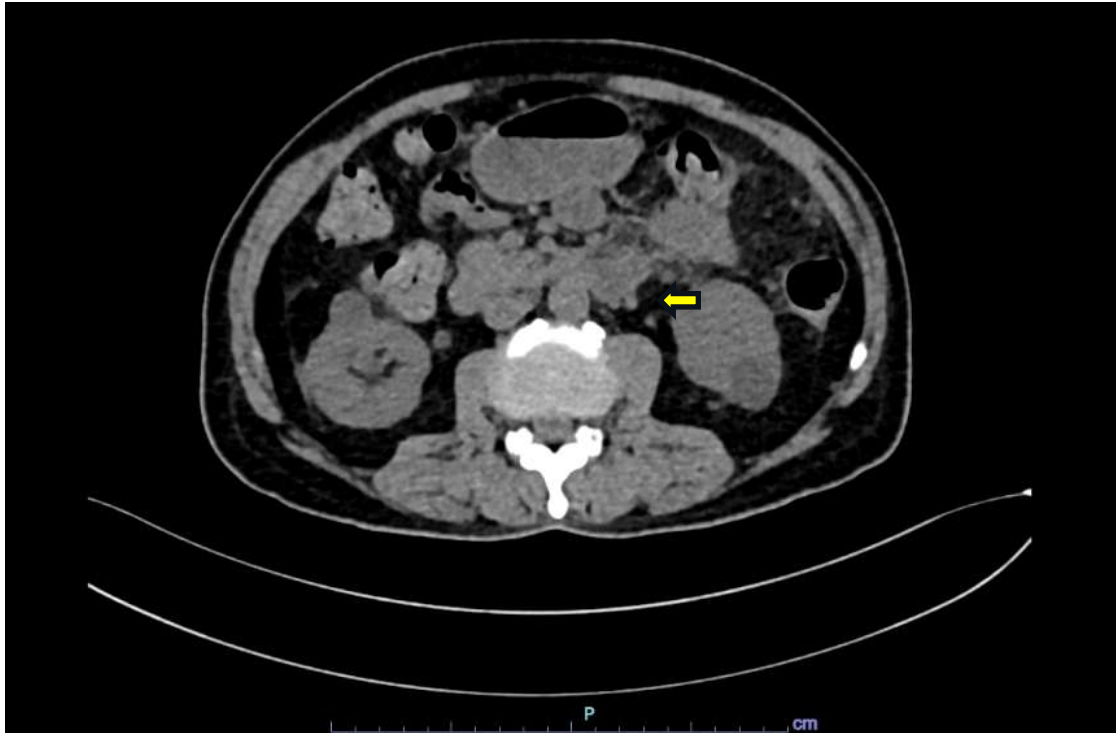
Resolution of fat stranding seen on Day11 in CT scan dated 08-05-2023.
